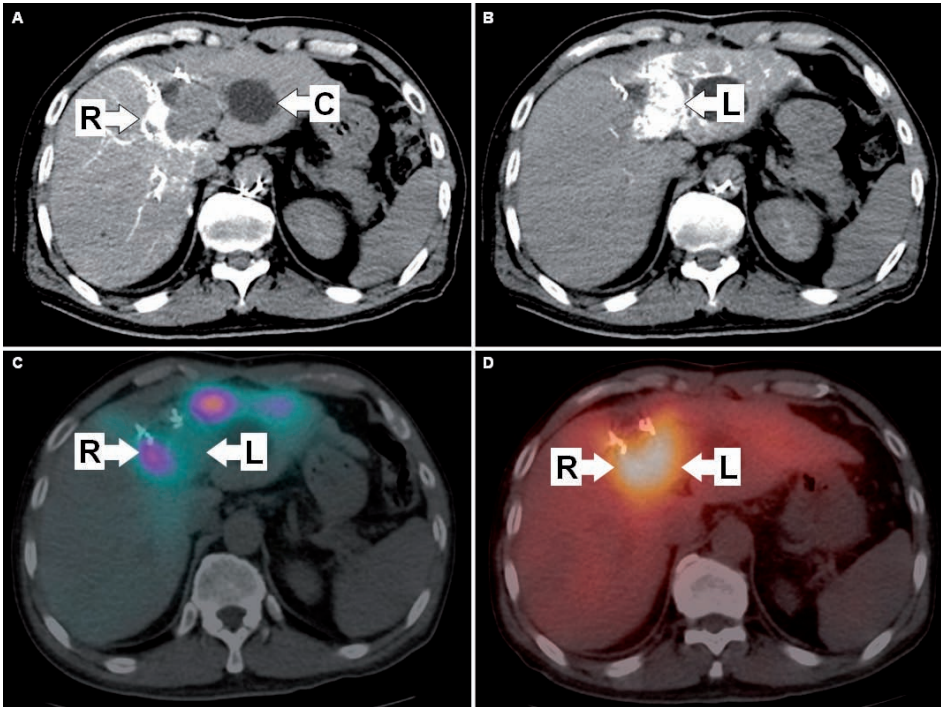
Patient 2: Example of sub-lesional dosimetry with left radioembolization lobectomy intent. The patient had recurrent HCC at the segment IV resection margin. Left lobe hypodensity is a cyst (A, 'C'). The tumor was supplied by the right and left hepatic arteries. Catheter-directed CTHA depicts the planning target volumes of the right (A) and left (B) hepatic arteries, dividing the dosimetric plan into two independent halves for sub-lesional dosimetry. ^{99m}Tc -MAA SPECT/CT showed good T/N ratio (6.1) of the lateral tumor portion supplied by the right hepatic artery (C, 'R'), but poor T/N ratio (1.4) of the medial tumor portion supplied by the left hepatic artery (C, 'L'). The dosimetric plan of the left hepatic artery planning target volume was deliberately escalated beyond safe limits to achieve a predicted mean radiation absorbed dose of 133 Gy to tumor and 93 Gy to non-tumorous liver, where progressive atrophy of the left lobe was the anticipated collateral effect i.e. left radioembolization lobectomy intent. Post-radioembolization bremsstrahlung SPECT/CT showed good tumoral activity in both lateral (D, 'R') and medial (D, 'L') tumor portions, indicating technical success.
